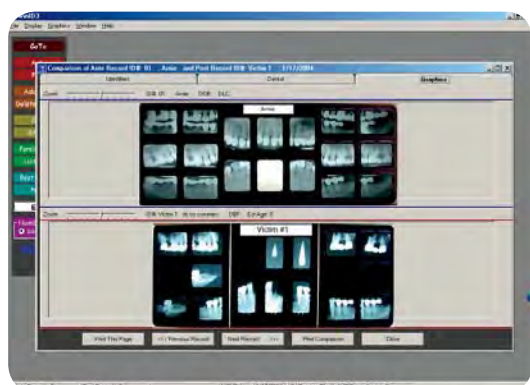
Comparison of dental X-rays – antemortem to postmortem. (Photo courtesy of Ray Johansen, DMD.)
